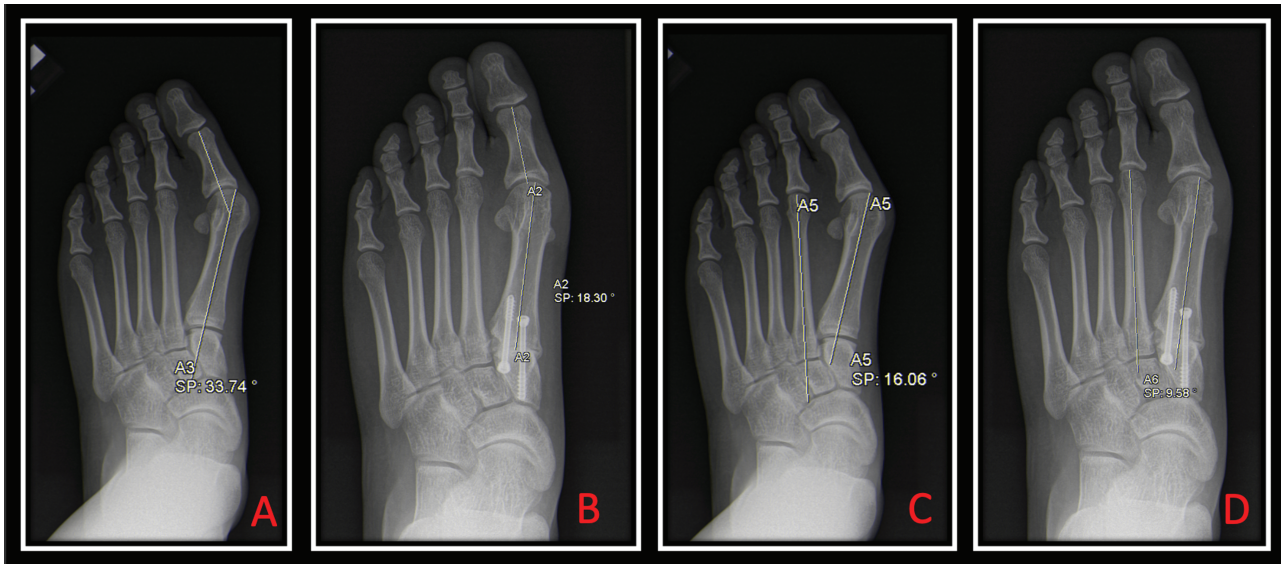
Standing AP pre- and postoperative radiographs of a 15-year-old female with hallux valgus who underwent a medial cuneiform/first MT fusion (Lapidus procedure) and distal soft tissue realignment. (A) Preoperative AP view shows HVA of 30 degrees. (B) Postoperative AP view shows HVA of 18 degrees. (C) Preoperative AP view shows IMA of 16 degrees. (D) Postoperative AP view shows IMA of 10 degrees.
